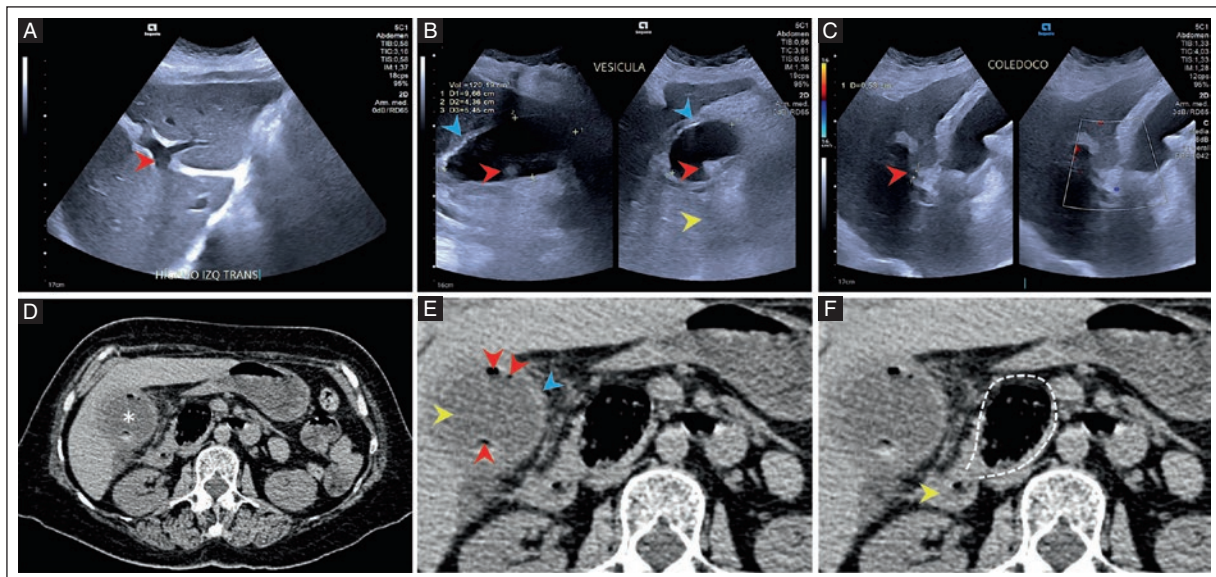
A 71-year-old woman with abdominal pain and jaundice diagnosed with Lemmel syndrome. A: grayscale US, transverse view of the left lobe of the liver showing intrahepatic bile duct dilatation (red arrowhead). B: grayscale US in split-screen mode with longitudinal and transverse views of a dilated gallbladder (9.6 × 4.6 × 5.4 cm, calculated volume of 120.2 cm³) with wall thickening (blue arrowheads) and hyperechoic images (red arrowheads) causing posterior acoustic shadowing (yellow arrowhead). C: grayscale US and color Doppler in split-screen mode with a longitudinal view of the common bile duct (red arrowhead) with a 5.3 mm diameter in its retroduodenal segment. D: non-contrast CT, axial view soft tissue window showing gallbladder enlargement (asterisk). E: non-contrast CT, axial view, soft tissue window shows gallbladder wall thickening (blue arrowhead), fluid content (yellow arrowhead), and gas (red arrowheads). F: non-contrast CT, axial view, soft tissue window shows a sac-like formation (dashed line) with food content and gas, originating from the second segment of the duodenum (yellow arrowhead). CT: computed tomography; US: ultrasound.
